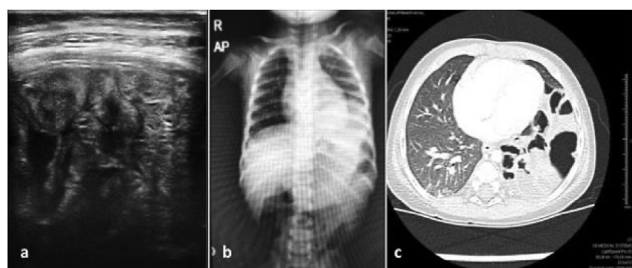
(a) CXR on admission: a left lower consolidation and possible effusion, (b) POCUS: bowel loops under the ribs instead of normal lung, and (c) Chest CT: bowel herniation in the left hemithorax.
